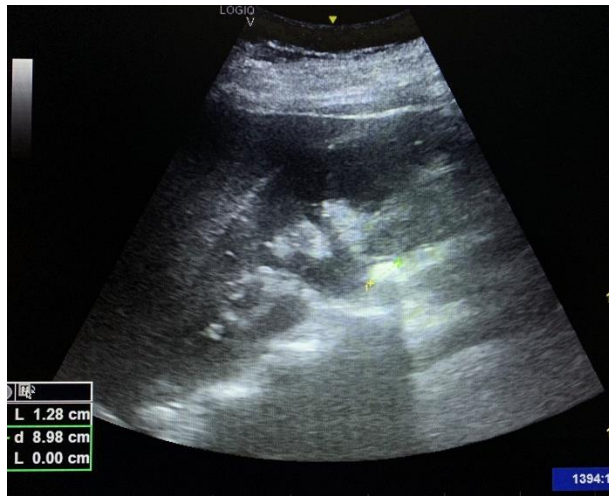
Kidney Ultrasound – uretero-hydronephrosis grade I secondary to a lumbar ureteral stone
